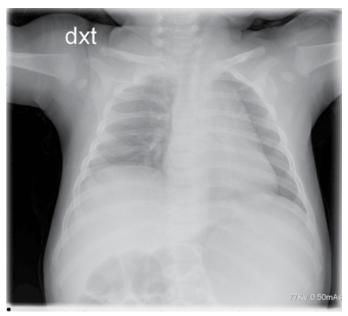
Chest X-ray on day-1 showing thin ribs and a raised right hemidiaphragm.
